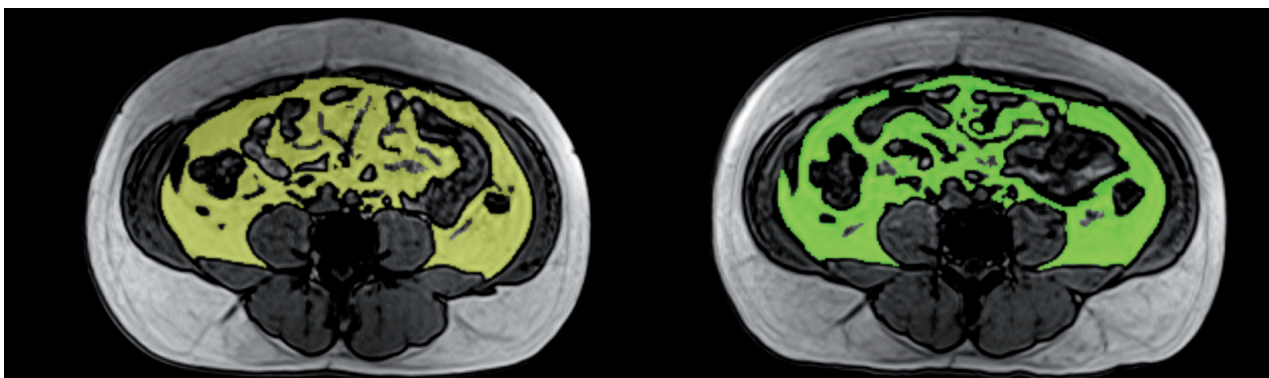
Visualization of visceral fat reduction, MRI image of a 34-year-old male taken at baseline (left) and at 3-month follow-up (right, a 16.4% reduction of VAT).
